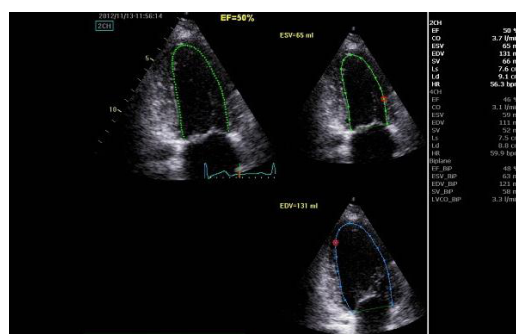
Echocardiogram (apical 2-chamber view) after discontinuing etanercept showing recovery in LV function.
